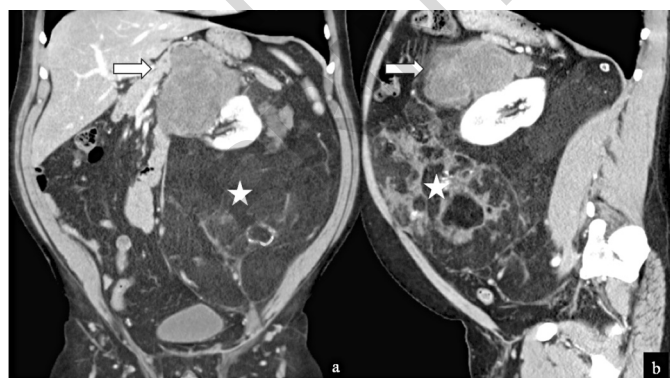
Well and de-differentiated liposarcoma. Contrast-enhanced coronal (a) and sagittal (b) CT images show a large heterogeneous fat-containing mass (asterisk) with solid enhancing component between left kidney and pancreas (arrow), according to de-differentiation.
